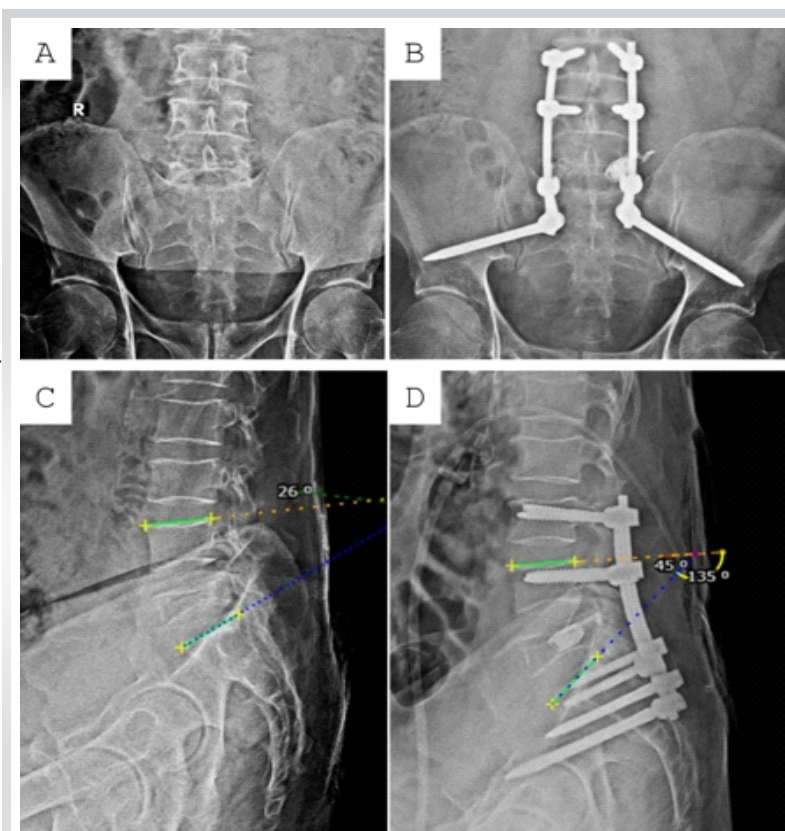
Comparison of pre-operative and 12th-month post-operative) Antero-posterior radiograph of lumbo-sacral spine showing instrumentation from L3 to S2-alari-iliac level with left-sided L5 stent (a and b), pre-operative and post-operative lateral radiograph showing improvement in local Cobb's angle from 26° to 45° (c and d).
